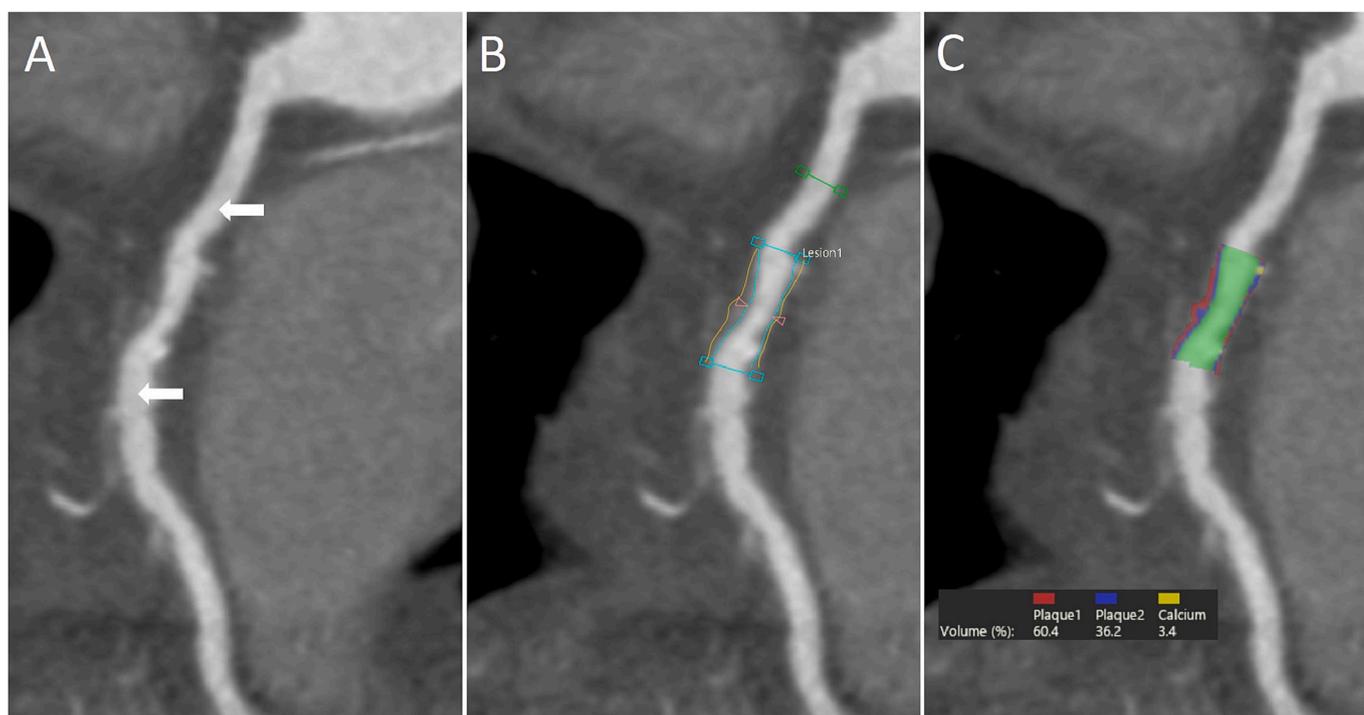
Defining a CT-TCFA (necrotic core/fibrous plaque ratio > 0.9). (A) Measurement of luminal contrast attenuation proximal and distal to plaque (white arrows). (B) Creation of vessel and lumen borders. (C) Quantification of plaque constituent volumes (red = necrotic core, blue = fibrous plaque, yellow = calcified plaque) using attenuation cut-offs for each plaque component calculated according to ratios of luminal contrast and plaque attenuation.
